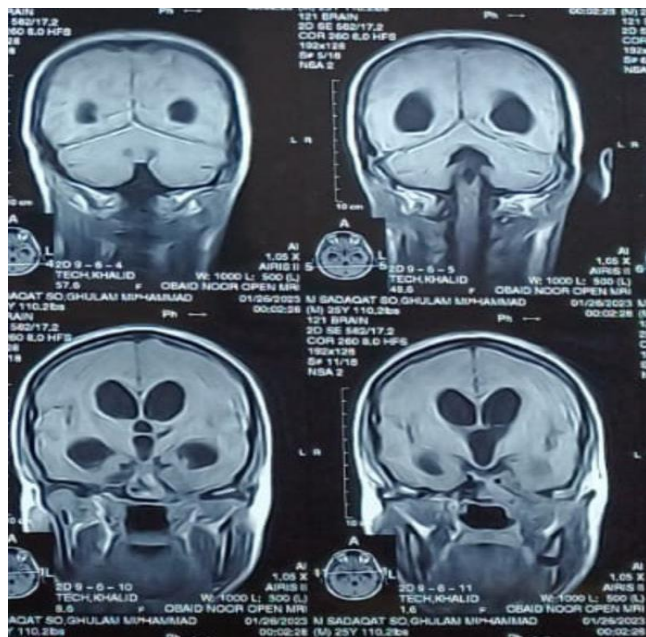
T1 diffusion-weighted MRI showing hypo to hyper intense supra sellar lesion.
